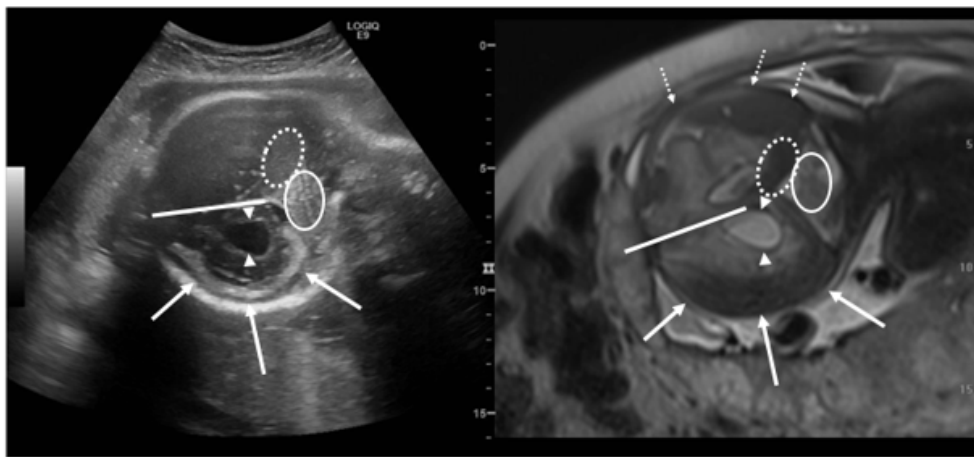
Fusion image of a fetus as a gestational age of 32 weeks in the coronal plane. On ultrasound the large subdural in the deeper half of the skull (white arrows) as well as the subdural hematoma on the superficial part of the tentorium (dashed circle) are clearly seen. The cerebellum is also depicted (white circle), In addition MRI demonstrates the hematoma in the superficial half of the skull (dashed arrows).
